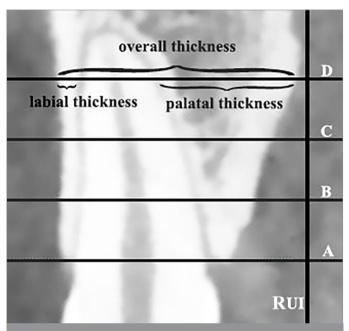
Measurements of alveolar bone thickness on a CBCT image. Same reference lines were used and same measurements were made on CBCT for all four incisors.
